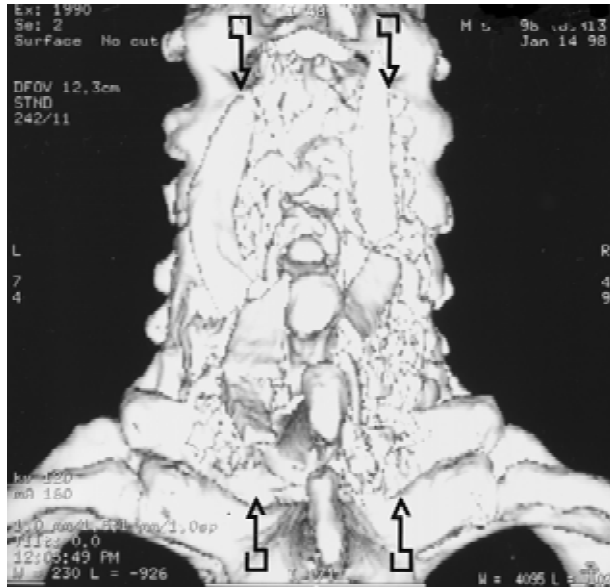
A three-dimensional CT shows posterior C3–T1 fusion (case 2) 3 months after the original surgery. The autogenous iliac crest bone applied during the posterior wiring and fusion clearly shows progressive incorporation and fusion (arrows).
